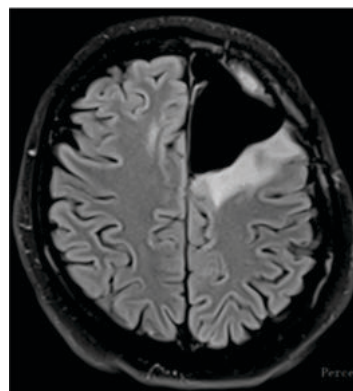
Axial FLAIR Images Showed CSF Intensity Lesion Causing Compression Of The Frontal Horn Of Left Lateral Ventricle.
